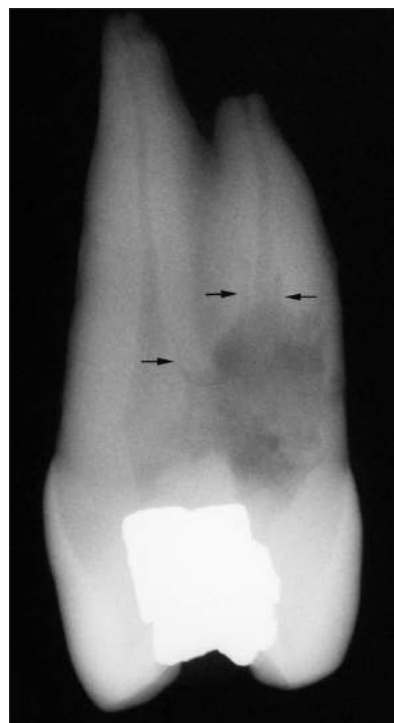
A proximal radiograph of this extracted tooth demonstrates a very large resorptive lesion that has resorbed a large part of the wall of the pulp chamber and palatal root canal. "Spider legs" are marked by arrows. The root of the extracted tooth appeared to be intact. A small resorption hole could be identified on the palatal surface of the root.
